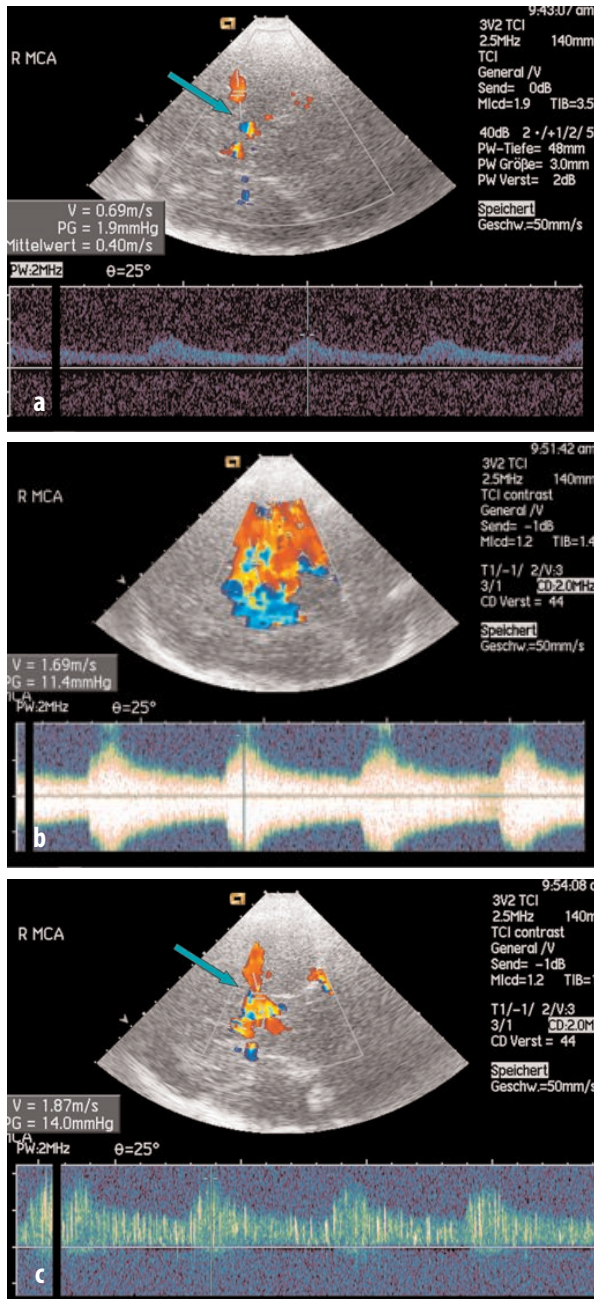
Stenosis of the right middle cerebral artery in a 60 year old patient with acute ischemia in the right middle cerebral artery territory. Extracranial ultrasonographic findings are shown in Figure 1 and 2. a Native transcranial color-coded image using a right transtemporal approach. The area of the stenosis of the right middle cerebral artery (MCA) cannot be visualized clearly (arrow). b Blooming effect after the injection of the contrast agent. c The stenotic region can be better displayed after application of the contrast agent SonoVue. The Doppler spectrum at the site of the stenosis shows an increase in angle-corrected maximum systolic flow velocity to 187 cm/s, indicating a moderate stenosis (the white signals in the Doppler spectrum represent the bubbles of the contrast agent SonoVue). d Magnetic resonance angiogram of the right MCA. The left MCA is filled by a hypoplastic left anterior cerebral artery (arrow) and shows a weak signal due to an extracranial occlusion of the left internal carotid artery at the origin. R MCA = right middle cerebral artery
